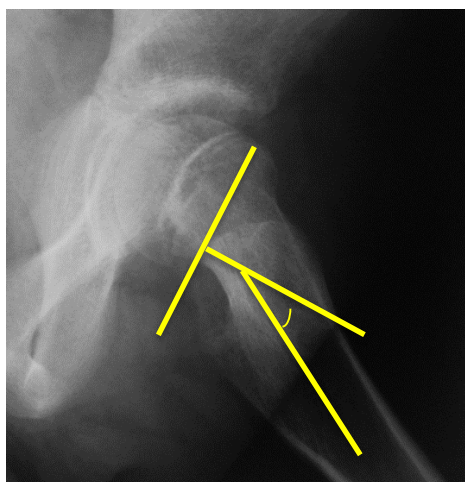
Frog leg lateral x-ray view showing measurement of Southwick neck-shaft angle.
